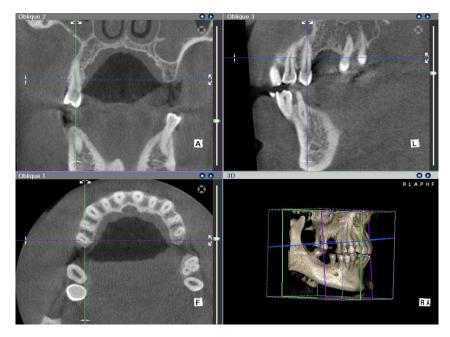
Sections (2×2mm) of CBCT (3D images denoted by axial, coronal and sagittal sections)
